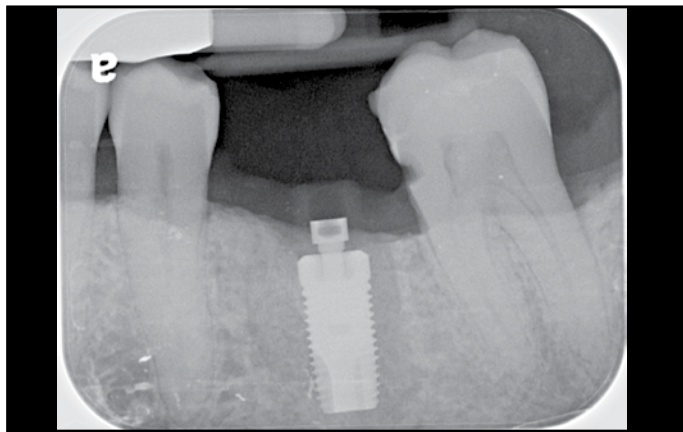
Radiograph of the placed implant.
